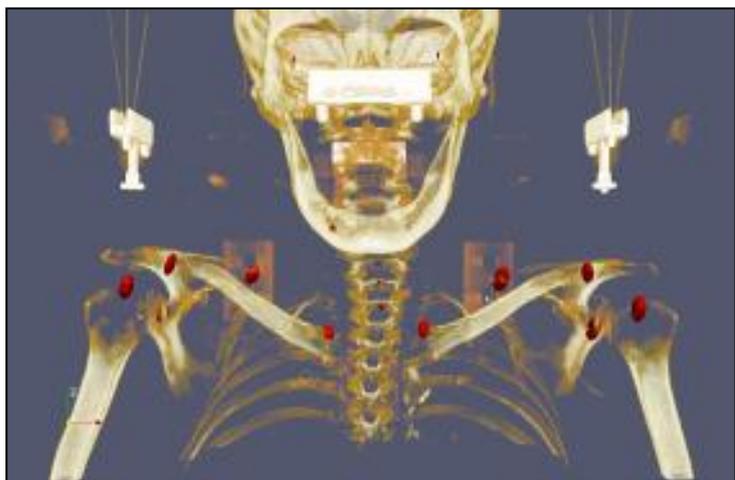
Ellipsoids having axes rotated to principle components of local deformations visualized together with volume rendering of a planning CT (frontal)
